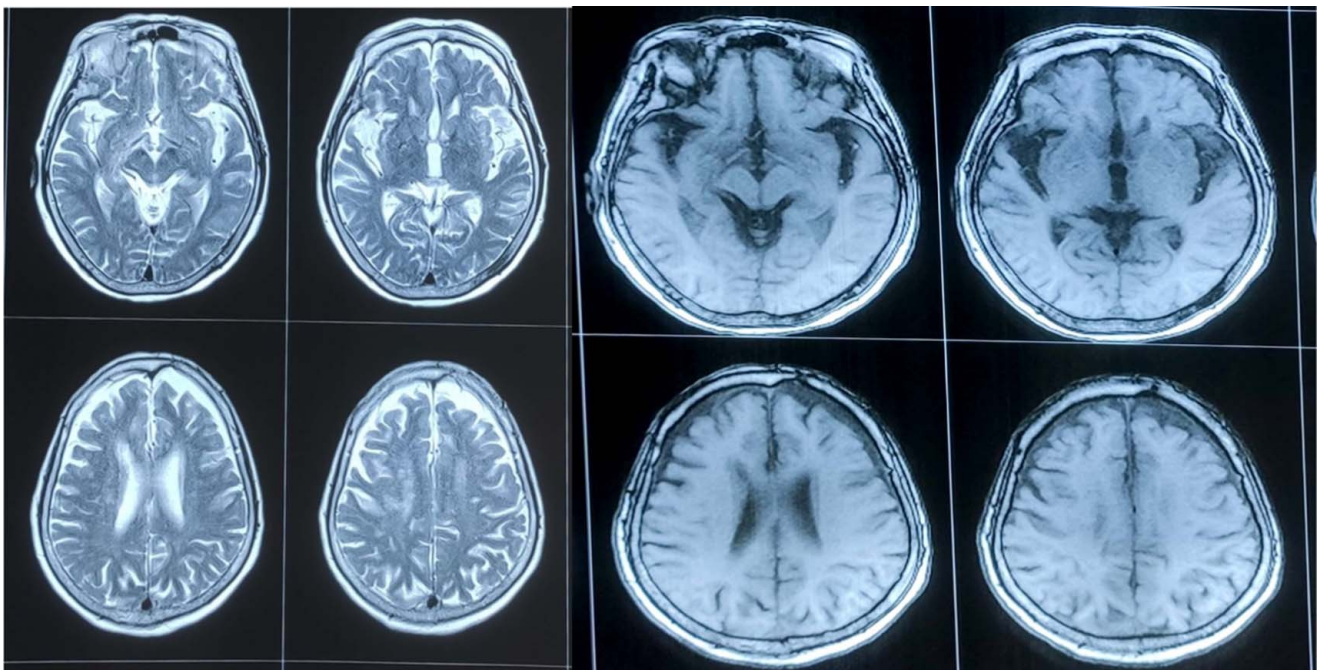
MRI brain T2 and FLIAR axial section suggestive of no any gross abnormality in the brain parenchyma. FLIAR, fluid attenuated inversion recovery.
